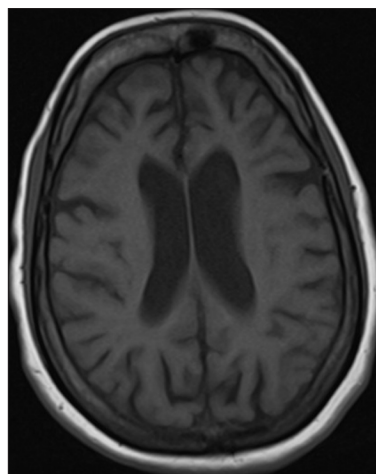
T1-weighted axial MRI-scan of the brain showing cortical atrophy and ex-vacuo dilatation of lateral ventricles
